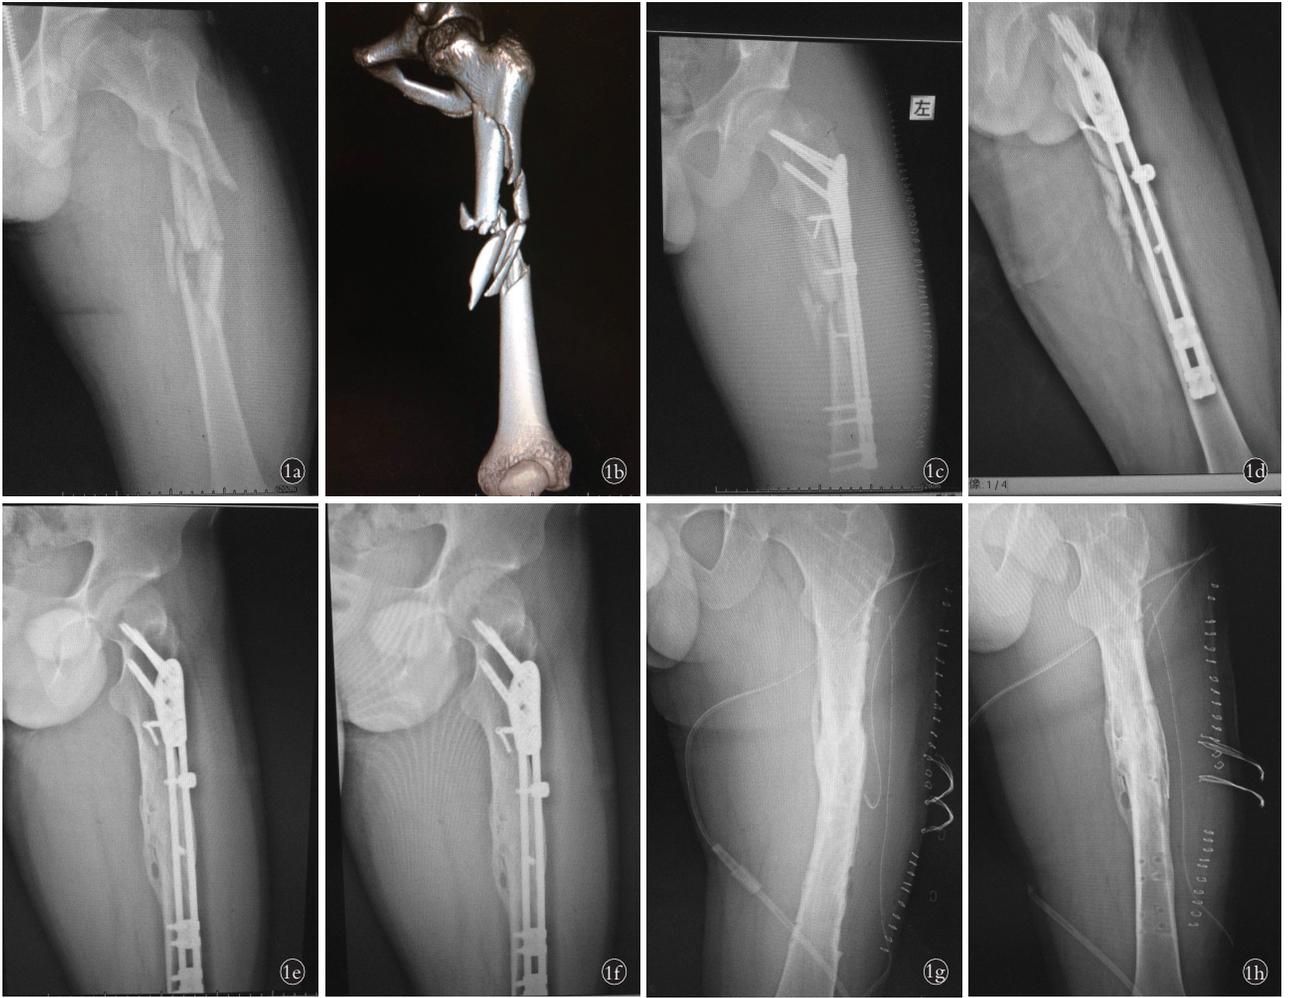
患者,男,52 岁,高空坠落致股骨干严重粉碎性骨折,合并股骨转子下骨折,行桥接组合式内固定 1a. 术前侧位 X 线片 1b. 术前三维 CT 重建 1c. 术后 1 周侧位 X 线片示内固定位置良好 1d. 术后 3 个月侧位 X 线片示内固定位置良好 1e. 术后 9 个月侧位 X 线片示内固定位置良好,骨折线模糊 1f. 术后 20 个月侧位 X 线片示骨折愈合 1g,1h. 术后 2 年内固定装置取出后正侧位 X 线片示骨折愈合
